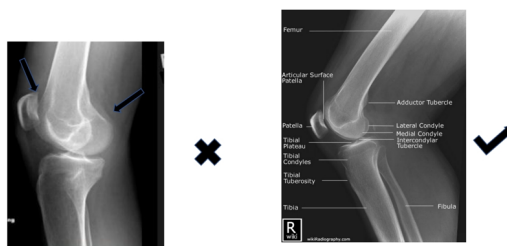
Incorrect and correct way to obtain Lateral Knee radiographs
